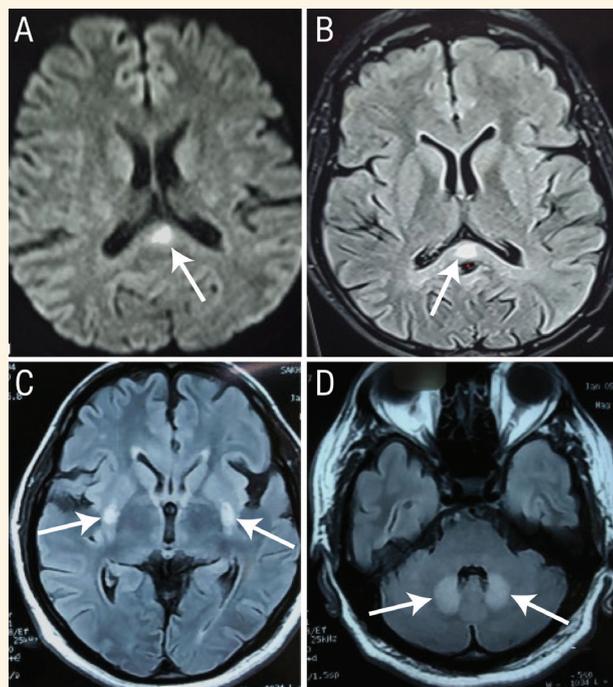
Magnetic resonance imaging scans of the brain of a 44-year-old male patient showing (A) the splenium of corpus callosum with evidence of diffusion restriction (arrow) and (B) hyperintensity (arrow) on fluid attenuation inversion recovery scans. Scans also showed (C) symmetrical areas of hyperintensity involving bilateral lentiform nucleus (arrow) and (D) dentate nucleus of cerebellum (arrow).
